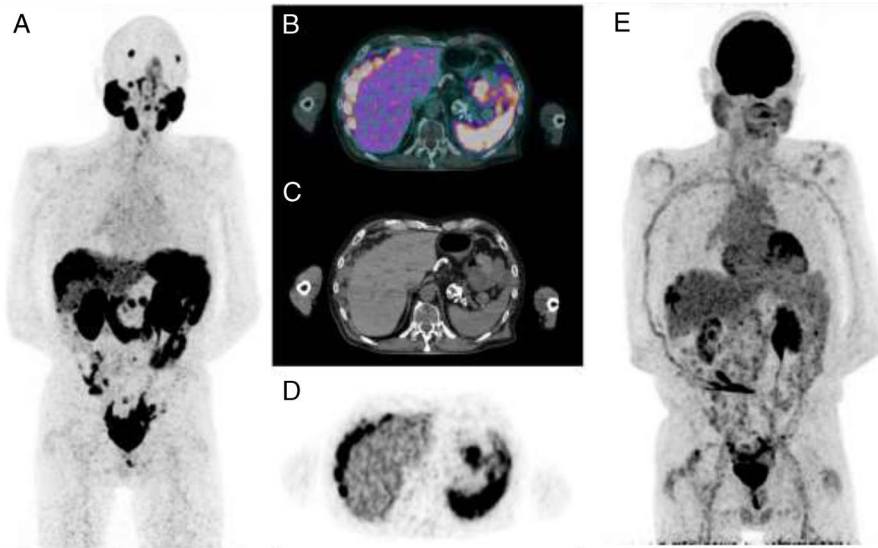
A 81-year-old man with metastatic castrate-resistant prostate cancer underwent a ^{68}Ga -PSMA-11 as a screening examination before ^{177}Lu -PSMA-1 therapy. Indeed his disease was getting worse despite 2 androgen receptor-directed hormonal therapies lines and 2 chemotherapy lines. The ^{68}Ga -PSMA-11 PET/CT performed for patient's screening therapy demonstrated an intense uptake of the known secondary peritoneal carcinomatosis (SUV_{max} , 12.7), notably in liver scalloping lesions (A, MIP; B, axial fusion; C, axial CT; D, axial PET). It showed no other uptake, especially in bone or lymph nodes. The man also underwent an ^{18}F -FDG PET/CT as screening examination, which displayed a moderate uptake in the peritoneal lesions, without any mismatch (E, MIP).
